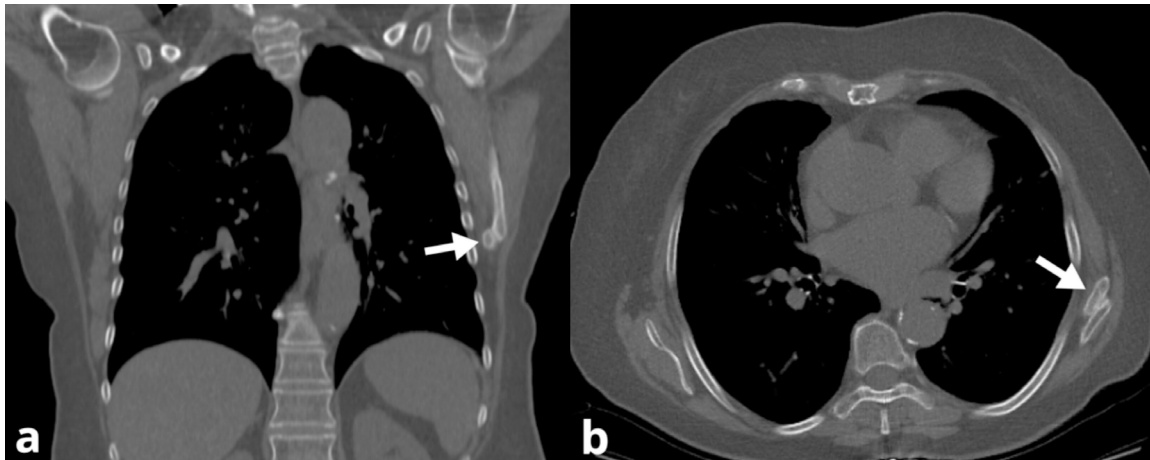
Coronal (a) and axial (b) CT images of the chest show a separate ossicle at the lower angle of the left scapula (arrow). Smooth and sclerotic contours distinguish it from fracture.
